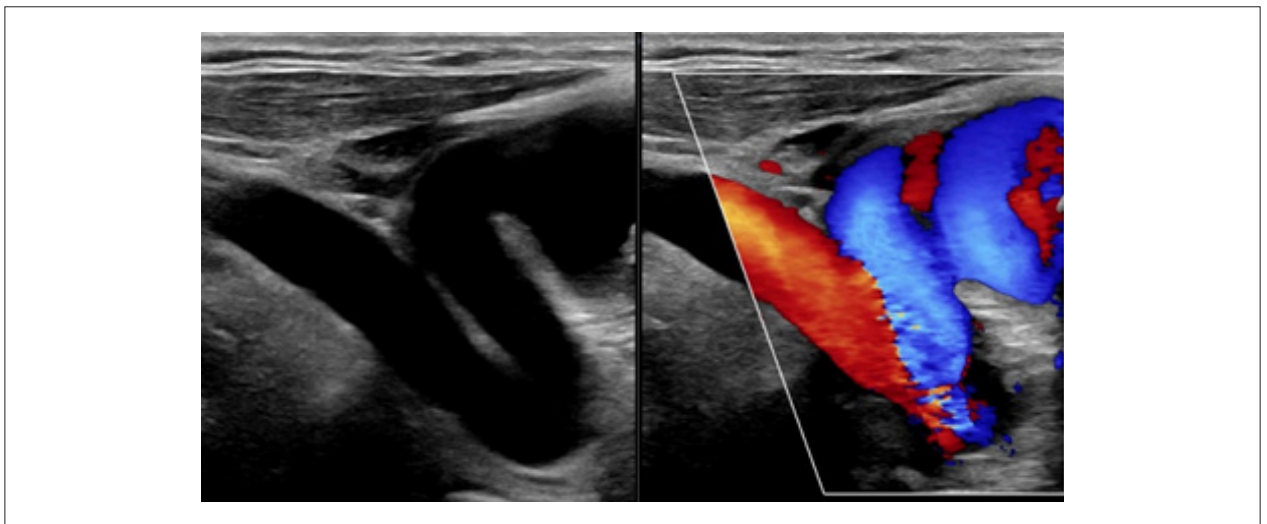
Arterial Doppler of left carotid and vertebral arteries showing common carotid origin kinking.
